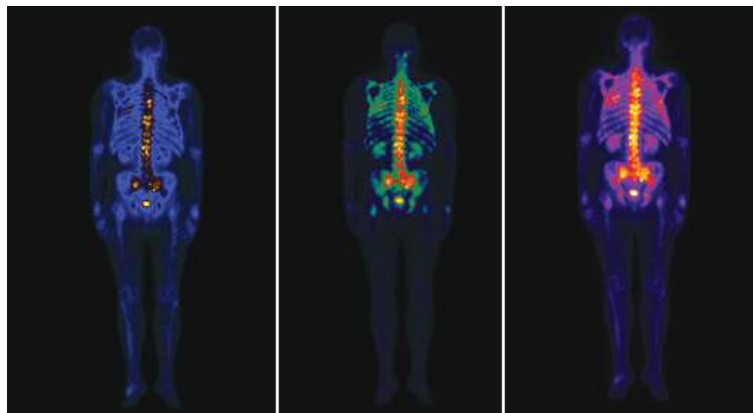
A sample of scintigraphy image represented by different colour palettes (Blue/Yellow, Blue/Green/Red/Yellow, Warm Metal).
